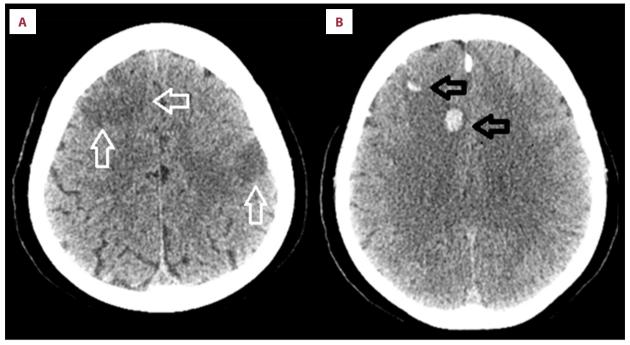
(A) Axial section of CT scan of the head shows hypodensities (white arrows) in right frontal, parietal, and left parietal regions, (B) multiple hemorrhagic foci noted (black arrows) in right frontal region.
